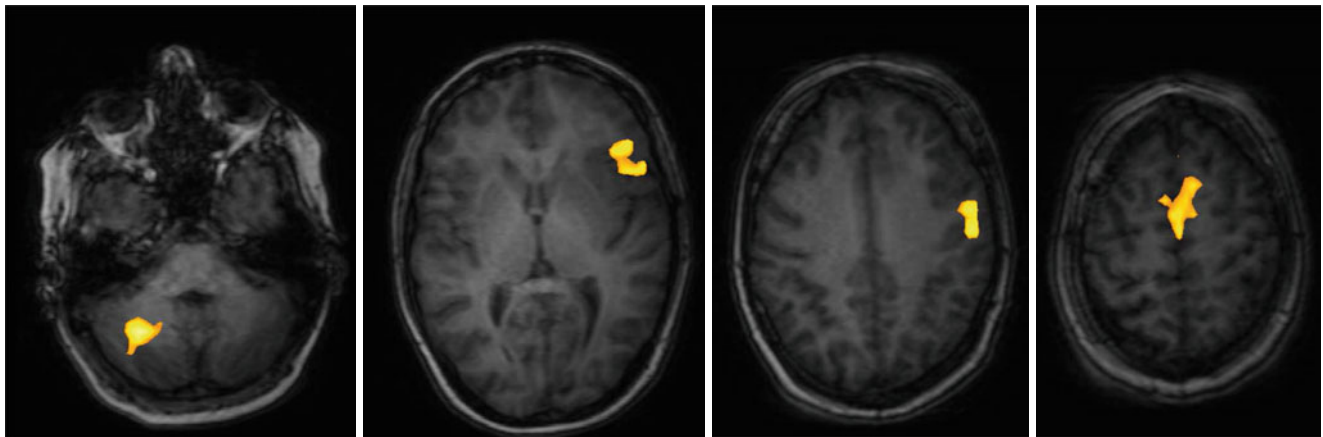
Language mapping by functional MRI; female, 45 years. – BOLD data superimposed on native T1 images (Courtesy of Wolfram Schwindt, Institute of Clinical Radiology, Münster)
